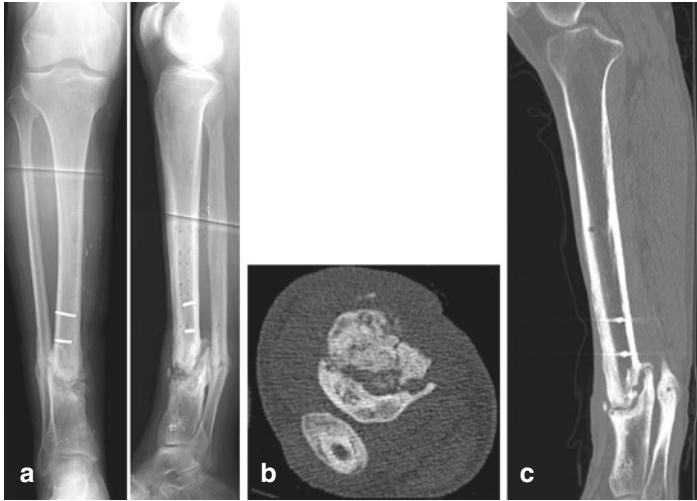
Radiographs and CT images from the patient's initial presentation to our institution reveal the presence of an unhealed right distal tibial nonunion with broken screw pieces embedded in the tibia. (a) AP and lateral radiographs of the right tibia. (b) Axial CT image of the right tibia. (c) Sagittal CT image of the right tibia
